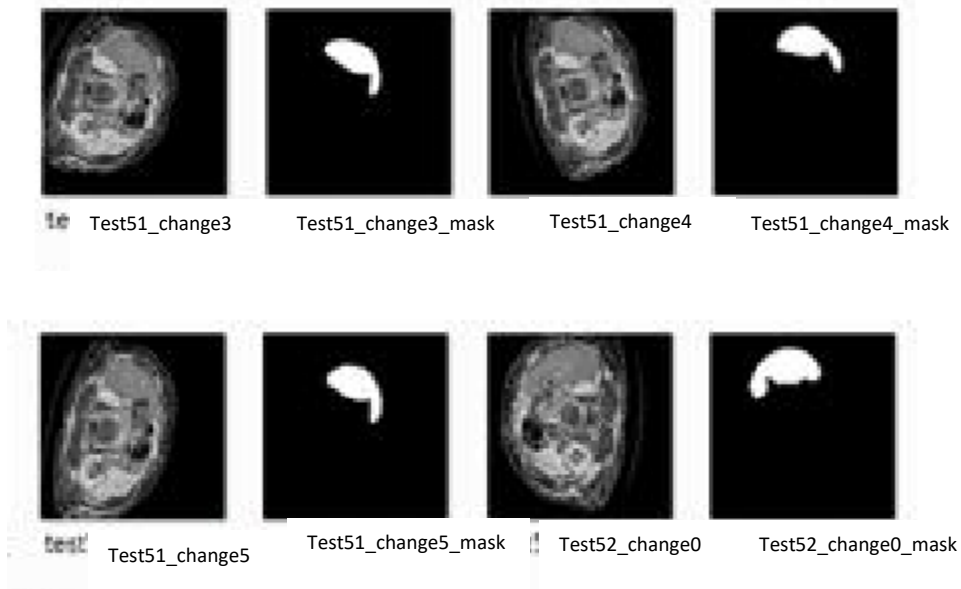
The effect of data augmentation on random CT images.
